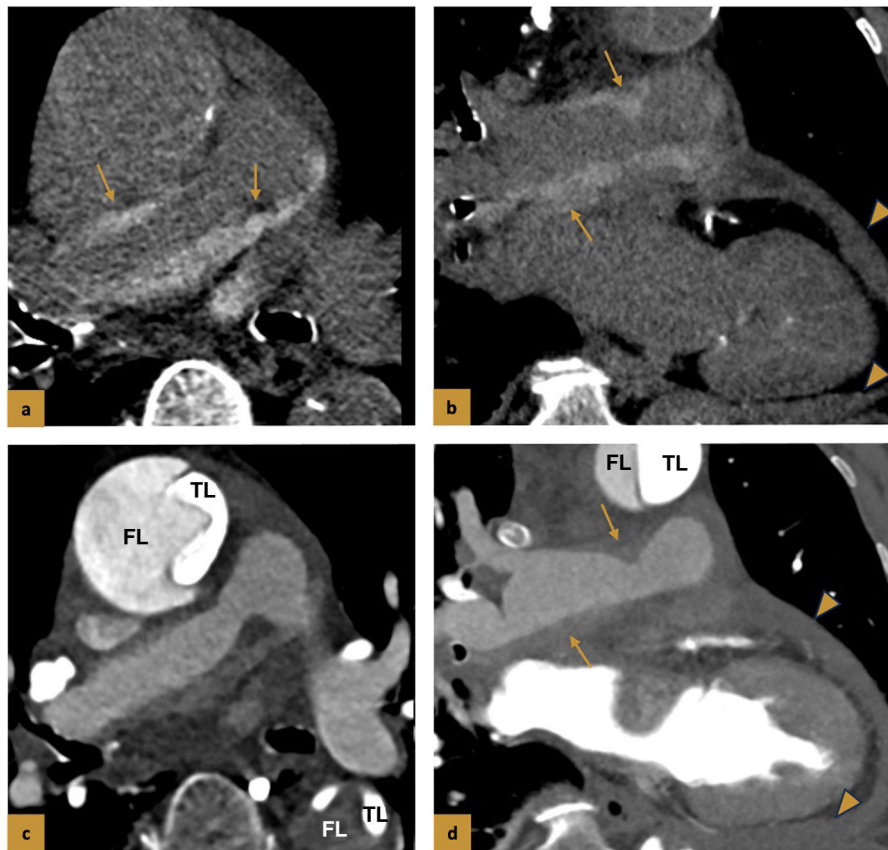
Type A aortic dissection with haematoma extending to the pulmonary artery adventitia. (a) and (b) Axial and coronal CT without contrast. Spontaneously hyperdense circumferential thickening surrounding the pulmonary artery trunk and extending to the right pulmonary artery (arrows). It is accompanied by a moderate haemopericardium (arrowheads). (c and d) Contrast-enhanced CT in the early arterial phase, axial and coronal slices, shows a dissecting flap separating two lumens, a very collapsed true lumen on the left lateral margin of the ascending aorta and anteriorly located in the descending aorta, and a highly pressurised false lumen. The peripheral thickening of the right pulmonary artery is more difficult to identify; the only notable feature is a slight mass effect on the lumen in the proximal segment secondary to the haematoma, which could go unnoticed if the non-contrast phase were unavailable.
